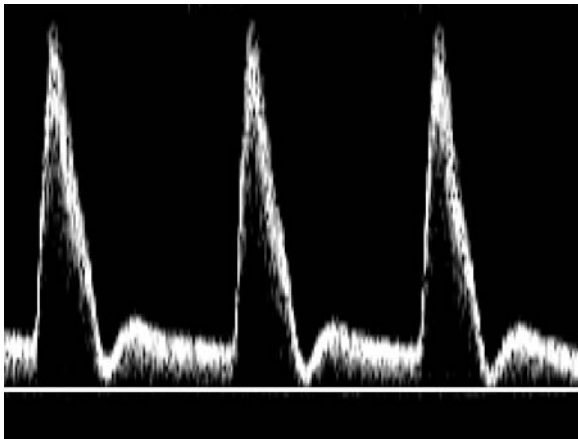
Triphasic (pulsed Doppler) waveform depicted with forward flow in systole, reverse flow (late systole/early diastole), and forward flow (late diastole).
